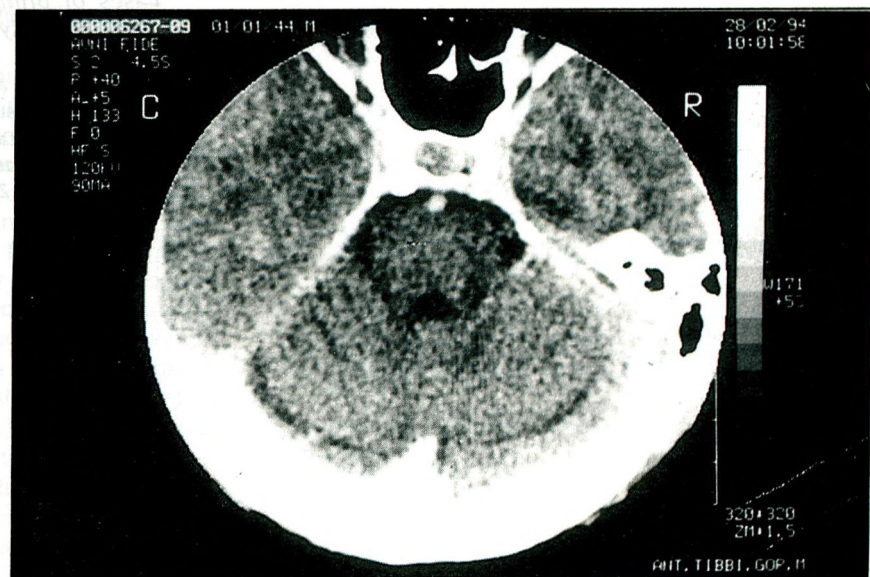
CT scan taken after two years and four months from the onset.
